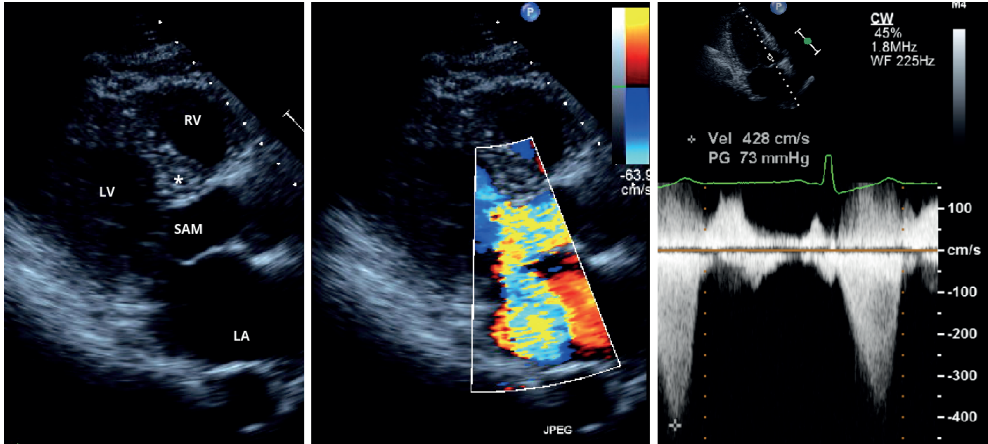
Preoperative 2D and doppler echocardiography, demonstrating a clear systolic anterior motion (SAM, left panel), severe mitral regurgitation (middle panel) and high left ventricular outflow tract obstruction (right panel). LA: left atrium; LV: left ventricle; RV: right ventricle.
